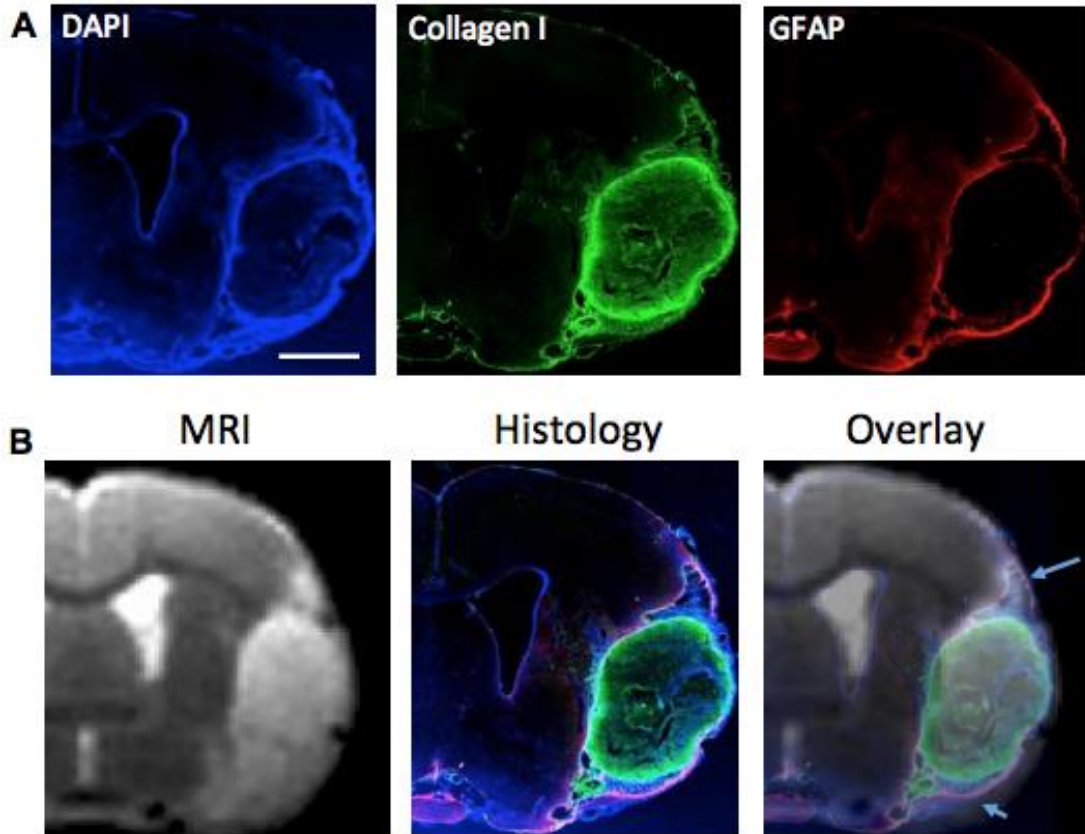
Correspondence between pre-implant MRI and post-mortem distribution of ECM hydrogel in the stroke cavity.
